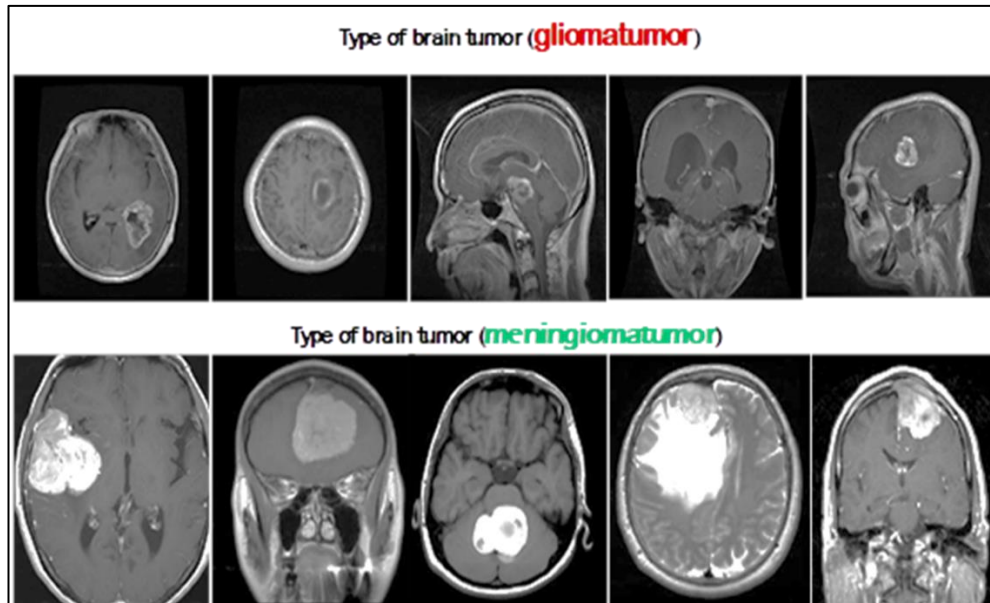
Normalized MRI scans depicting various tumor forms on various planes
